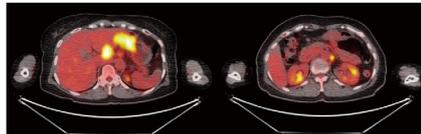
(A) of Case 1 : Initial PET/CT shows increased FDG uptake in the lower body to distal antrum.(Left) Hypermetabolic lymph node in the left paraaortic area is seen.(Right)
